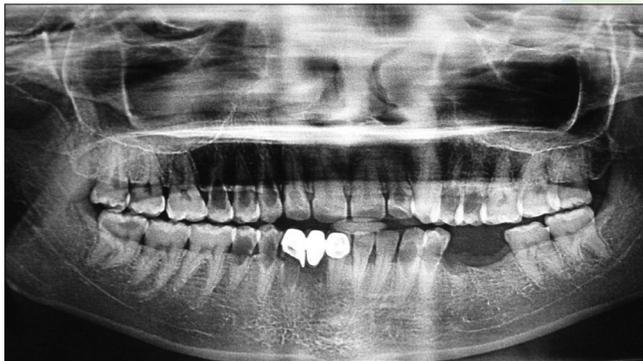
Orthopantomogram showing widening of pulp chamber and root canal
